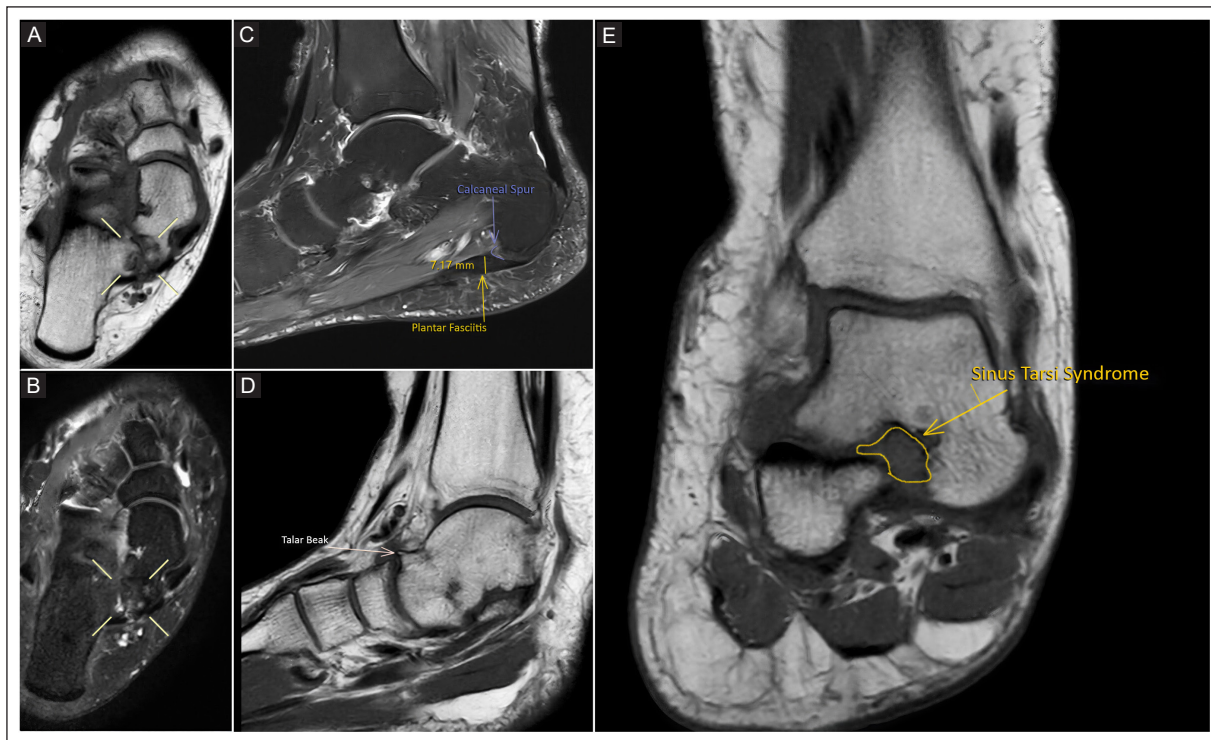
A-B: axial MRI T1-weighted and fluid-sensitive sequences, respectively. Findings are consistent with a non-osseous tarsal coalition. C: sagittal MRI fluid-sensitive sequence demonstrating thickening of the plantar fascia and the presence of a calcaneal spur as indirect signs of pathology. D: sagittal MRI T1-weighted sequence showing a talar beak at the dorsal aspect of the talonavicular joint as another indirect sign. E: coronal MRI T1-weighted sequence demonstrating loss of normal fat signal within the sinus tarsi, consistent with sinus tarsi syndrome.
